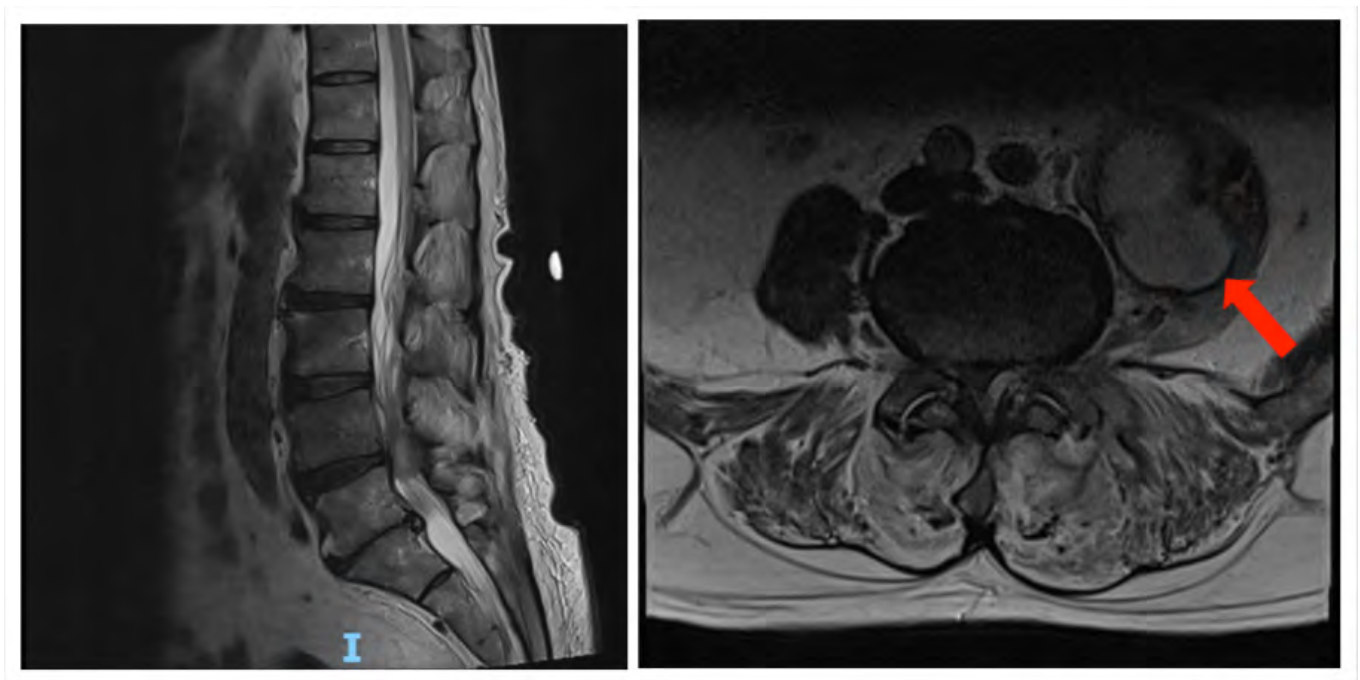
MRI of lumbo-sacral spine showing left facet joint septic arthritis complicated by a 2.4cm left para-facet joint abscess and a 5.1cm left psoas abscess with the extension of the abscess into the L4 and L5 epidural spaces (Red arrow showing psoas abscess)
